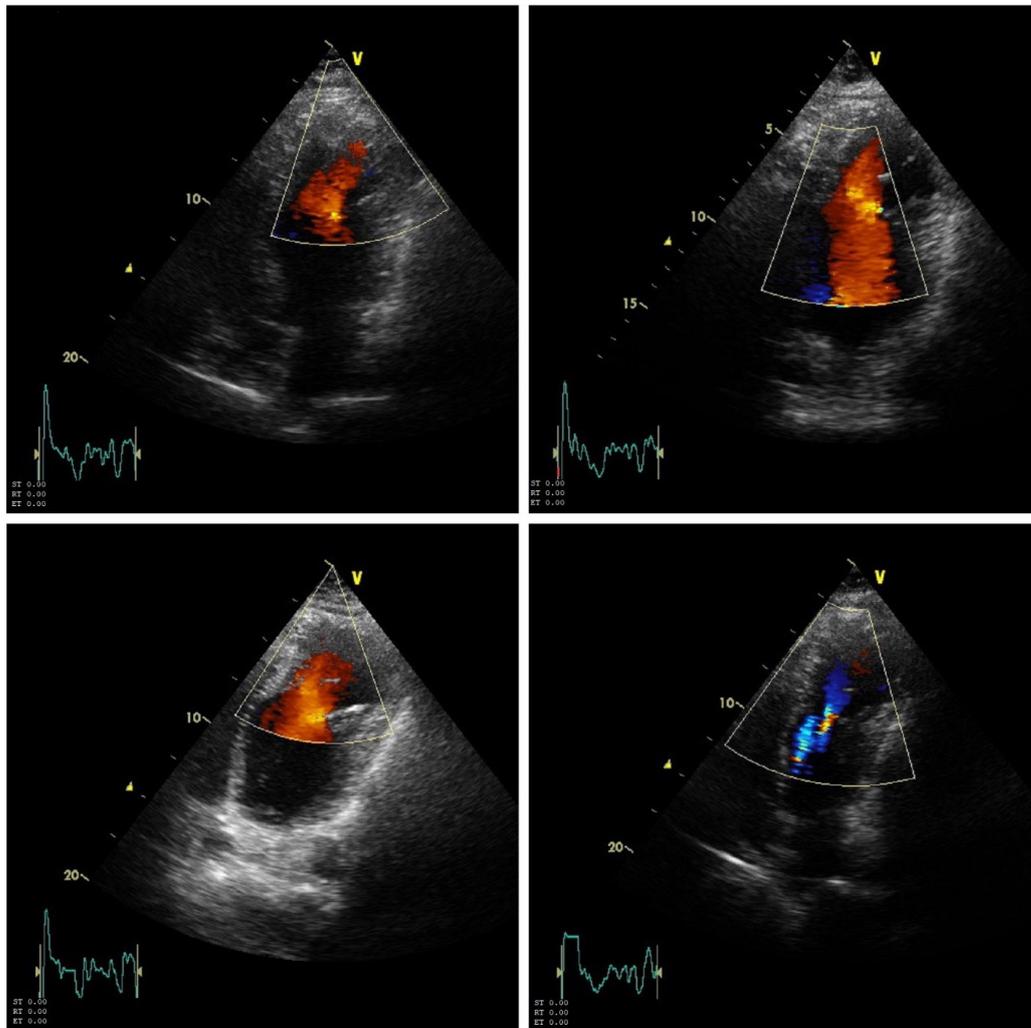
Color doppler flow imaging of left ventricular of the same patient.
